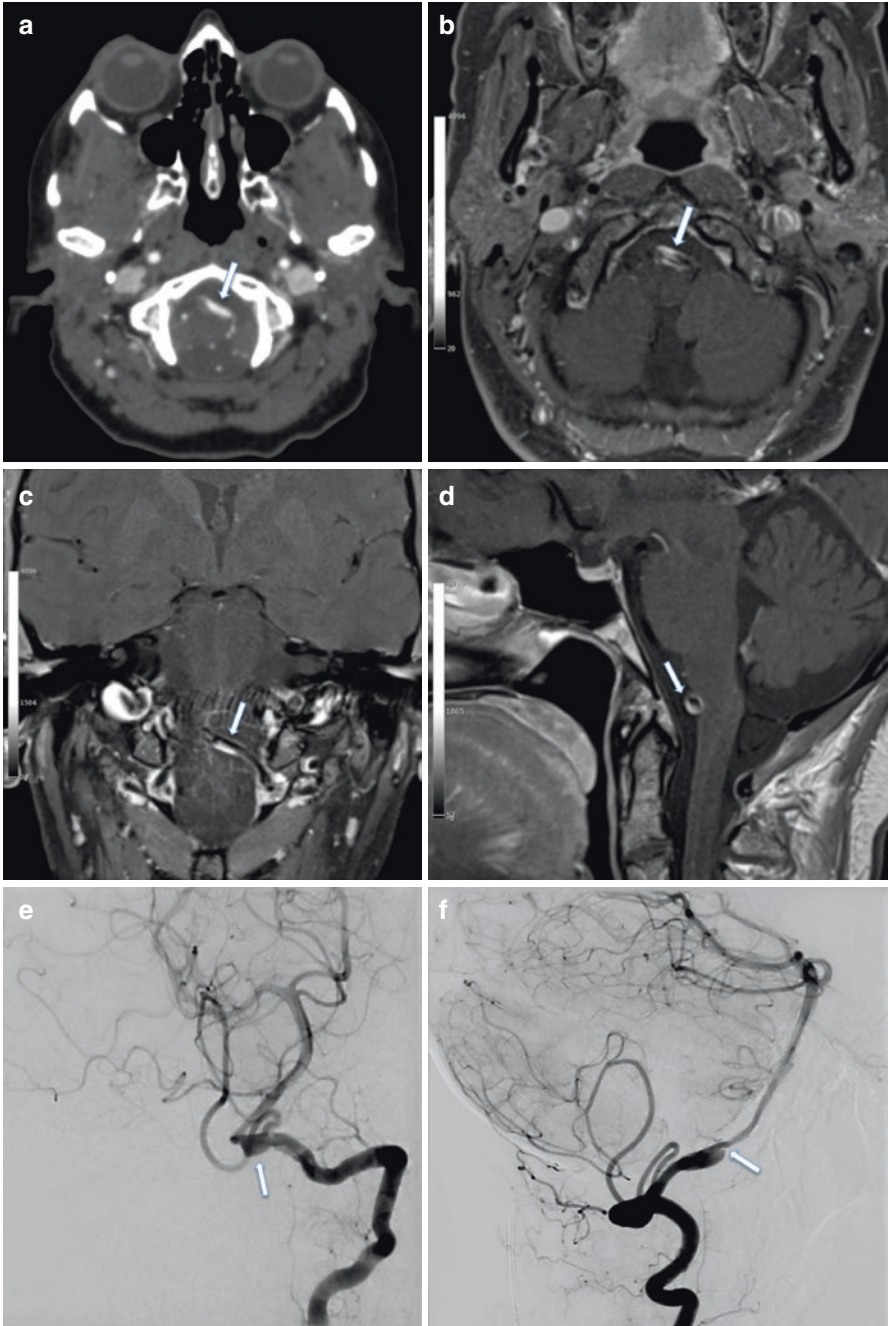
A patient with an incidental left V4 segment fusiform dissecting aneurysm (arrow in a). On post-contrast T1-weighted sequence, the mural hematoma (arrow in b–d) can be appreciated. The digital subtraction angiography (DSA) with a left vertebral artery injection shows clearly the vessel dilatation (arrow in e) and the dissection flap (arrow in f). A decision was made to treat conservatively
